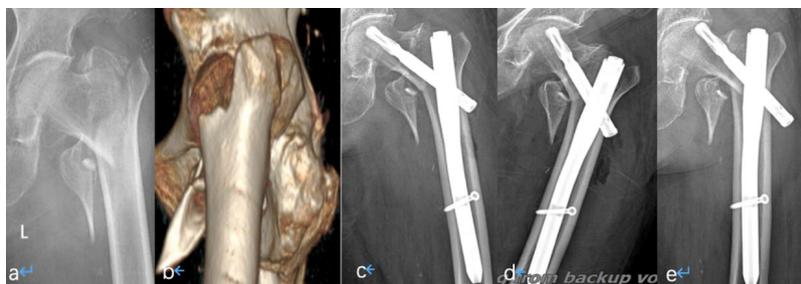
A 73-year-old male diagnosed with an intertrochanteric fracture. (a–b) Preoperative imaging showing intertrochanteric fracture with coronal fracture. (c) X-ray at 1 day postoperatively; (d–e) X-rays at 6 and 12 months postoperatively, showing screw cut-out and back-out.
